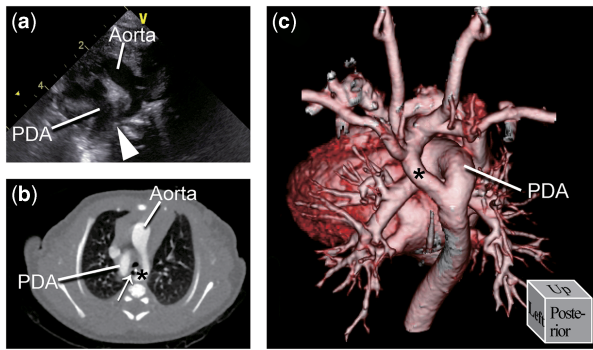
Postnatal imaging studies. (a) The suprasternal view of echocardiography shows an obscured aortic isthmus (arrowhead). (b and c) Contrast-enhanced CT at 2 days of age. A left-sided aortic arch connects to the right-sided descending aorta via a retro-oesophageal segment (*). Together with a right-sided ductus arteriosus, a vascular ring is formed, which encircles the trachea and oesophagus (arrow). PDA = patent ductus arteriosus.
